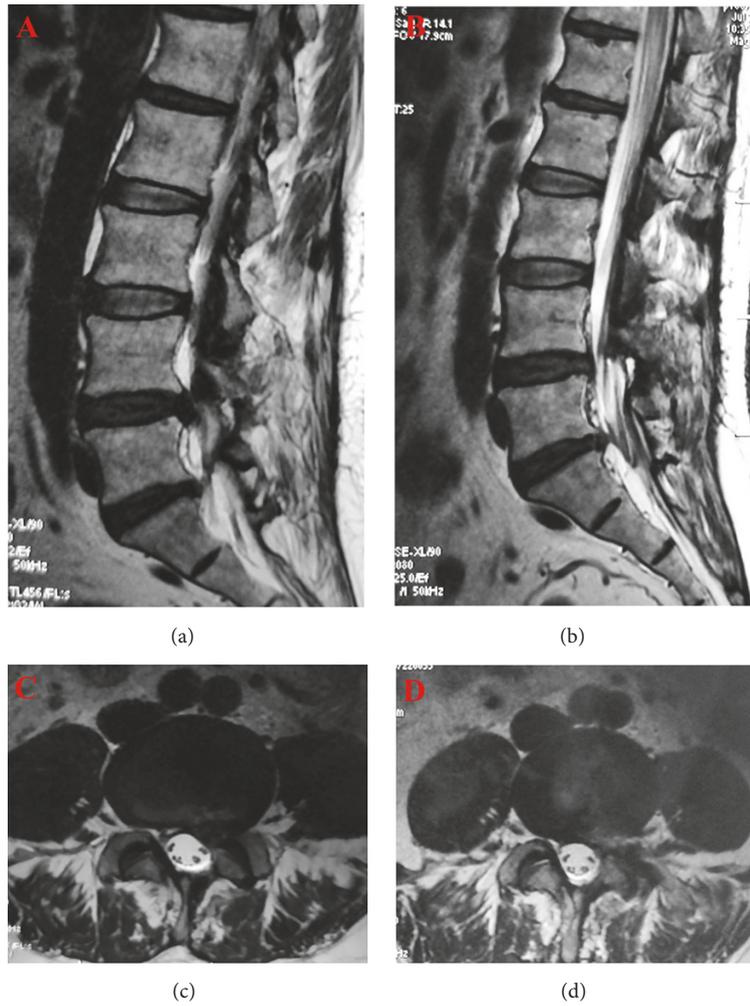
In the preoperative MRI, the sagittal (Panel (a)) and axial (Panel (b)) planes of T2-weighted imaging showed a lumbar disc herniation at the level L4/5. The decompression was satisfactory, which was confirmed at the sagittal (Panel (c)) and axial (Panel (d)) planes of the postoperative MRI.
